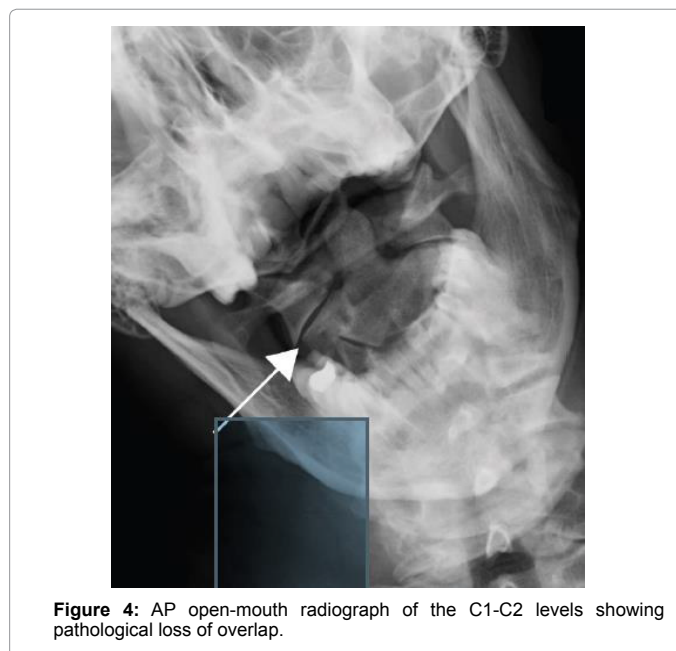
AP open-mouth radiograph of the C1-C2 levels showing pathological loss of overlap.
